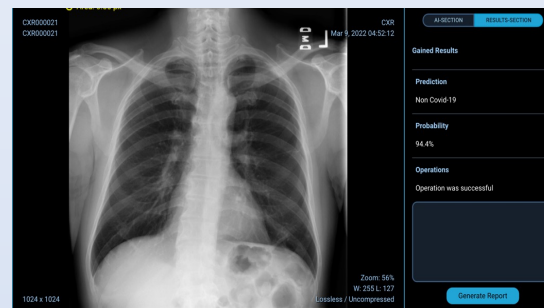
Chest x-ray show negative result for Covid-19 infection
